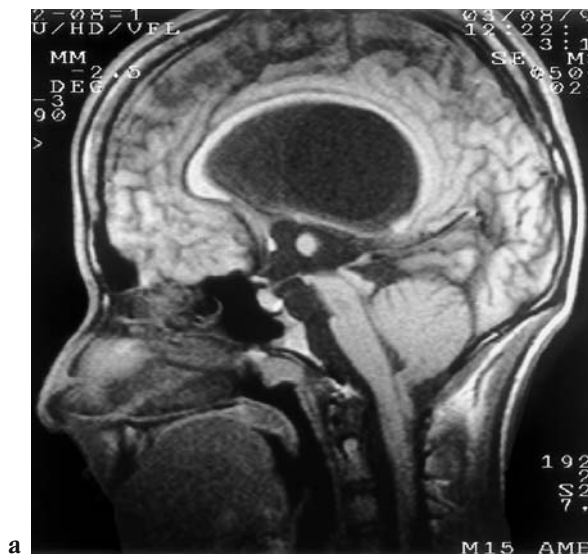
Mesencephalic tuberculoma with obstructive hydrocephalus. The MRI shows a contrast enhancing mass lesion of the posterolateral midbrain resulting in stenosis of the aqueduct of Sylvius and obstructive hydrocephalus. [a] axial T2-weighted and b) sagittal T2-weighted MRI; c) coronal T1-weighted MRI following IV Gd].
